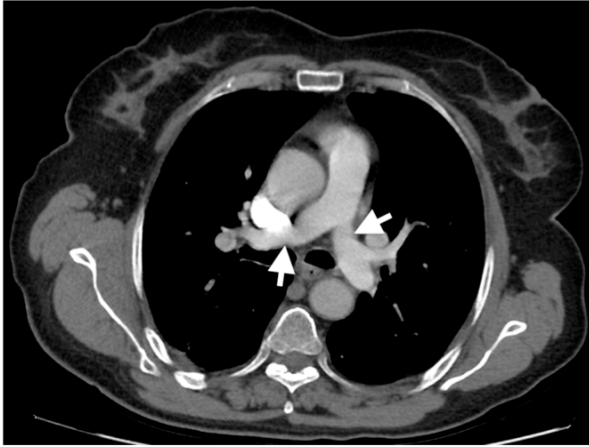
Contrast enhanced axial CT of patient after anticoagulant treatment demonstrates bilateral contrast material filled pulmonary arteries (arrows). No thrombus was observed in the pulmonary arteries.
